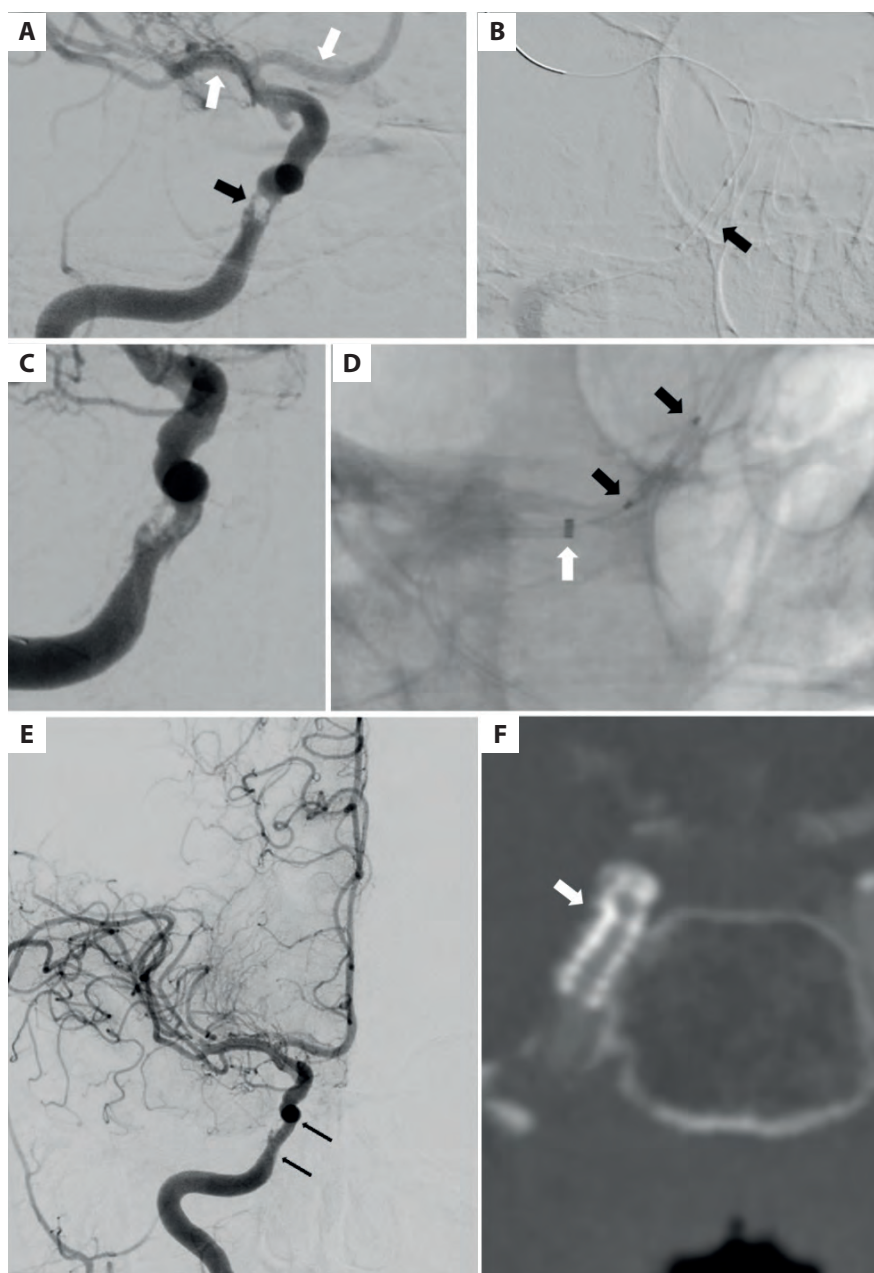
A. Angiography of the right internal carotid artery, critical calcified stenosis in the cavernous (C4) segment (black arrow); white arrows point to the middle and anterior cerebral arteries. B. Lithotripsy balloon at the level of the target lesion, black arrows show proximal and distal markers of the device. C. Control angiography after 5 minutes; recoil with visible dissection. D. Stent prepared for implantation, white arrow points to the end of aspiration catheter, black arrows point to the stent markers. E. Control angiography in the anteroposterior view after stent implantation; good result with minor residual stenosis and good inflow to the right anterior and middle cerebral arteries, yet without communication to the left cerebral hemisphere; arrows show implanted stent. F. Control computed tomography angiography, patent stent with minor residual stenosis and good inflow to the arteries of the right cerebral hemisphere
